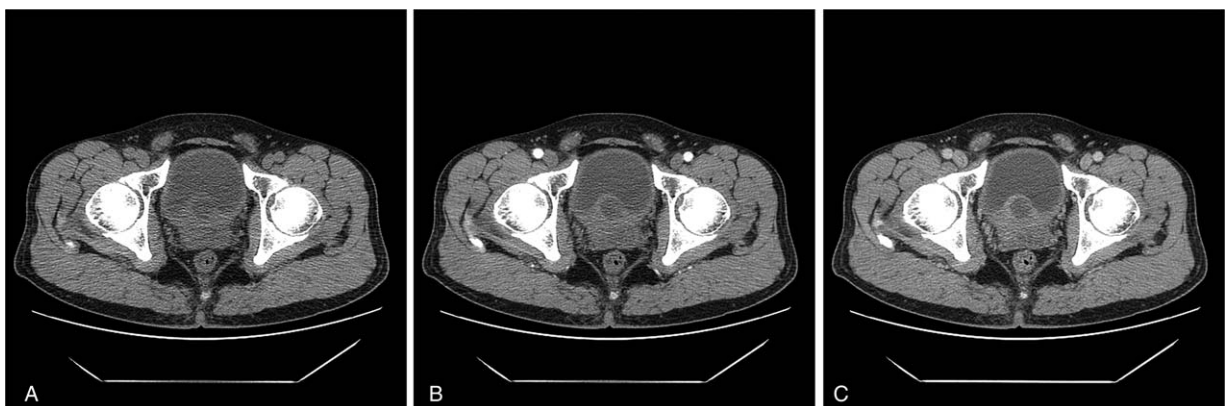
Conventional CT image showing a soft tissue mass in the prostate (A). Contrast-enhanced CT scan showing gradual enhancement of sections in the arterial phase (B) and venous phase (C). CT=computed tomography.
